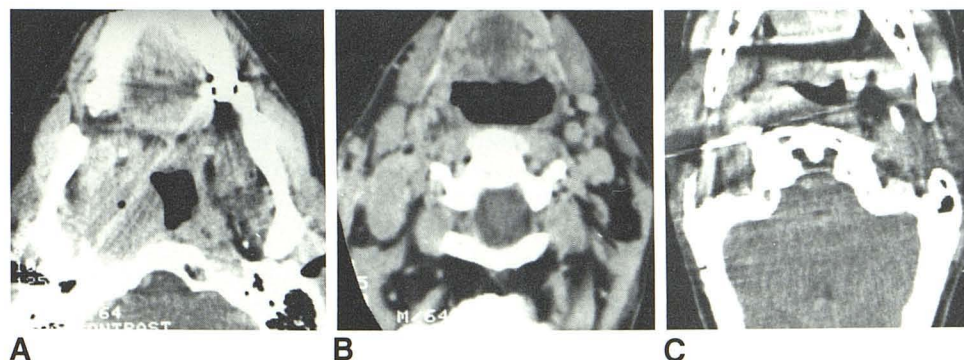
Extensive nasopharyngeal cancer. A and B, Nasopharyngeal carcinoma with submucosal extension into oropharynx to level of base of tongue was not apparent clinically. Adenopathy is also seen. C, CT section from multiple biopsies at various levels in nasopharynx and oropharynx confirms more extensive tumor seen in A and B.
